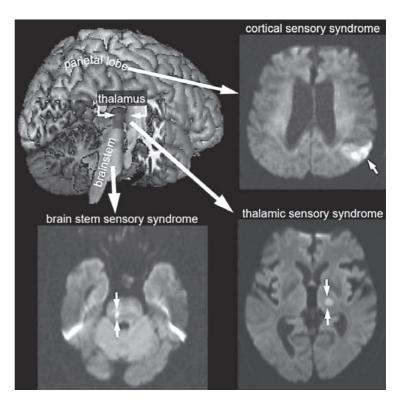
MRI lesion examples (diffusion-weighted imaging) for different sensory syndromes.
